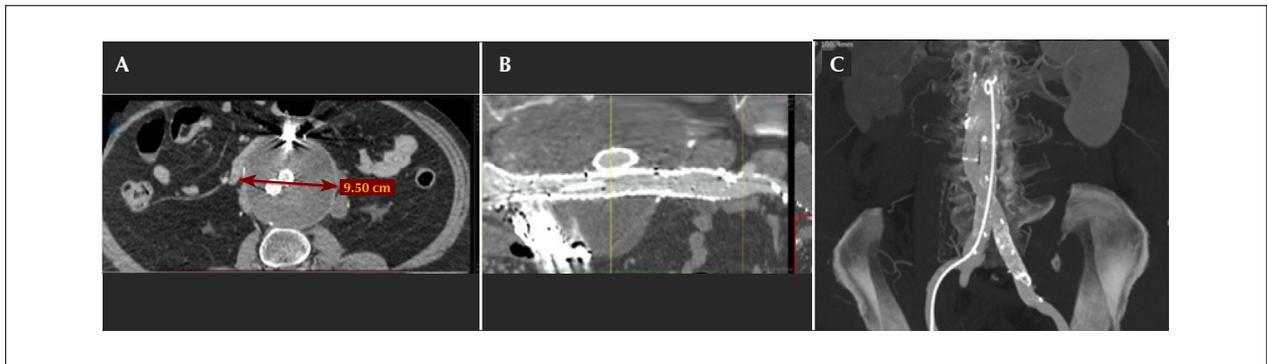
(A) Computed tomography angiography (CTA) image taken in the sagittal plane demonstrating the anteroposterior diameter of the aneurysmal sac. (B) CTA image taken in the coronal plane. (C) CTA image taken in the sagittal plane.
